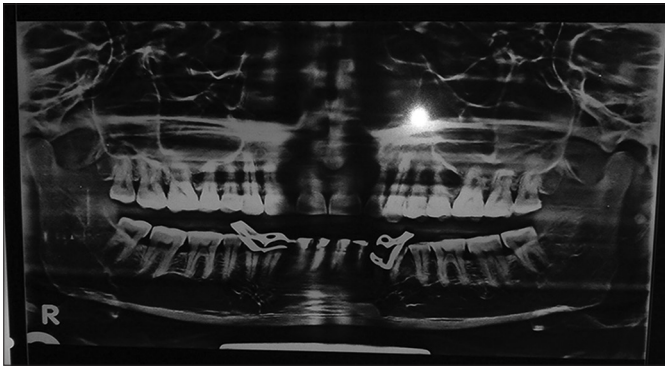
Orthopantomogram showing obturation with all the mandibular incisors.
